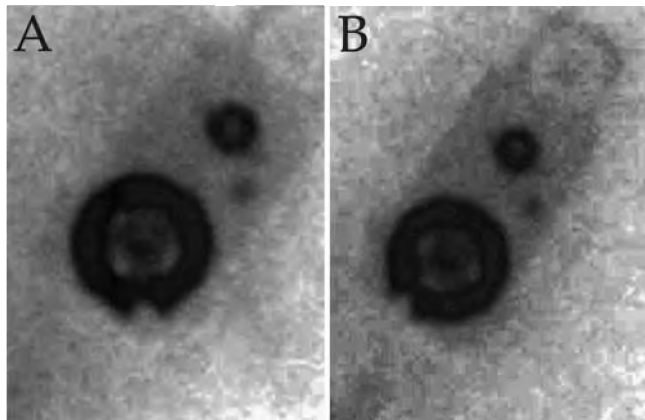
Radiographs demonstrating the Codman programmable valve before (A) and after (B) the patient's exposure to the toy magnets. The initial valve setting (A) was 70 cm H₂O and the adjusted setting (B) was 110 cm H₂O.
